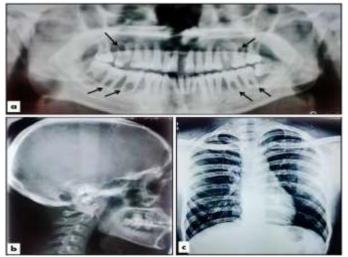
Panoramic dental tomography showing generalised bone loss extending up to apical third of roots (a); true lateral skull did not show any lytic lesion (b); Chest radiograph findings were negative for tuberculosis (c)
